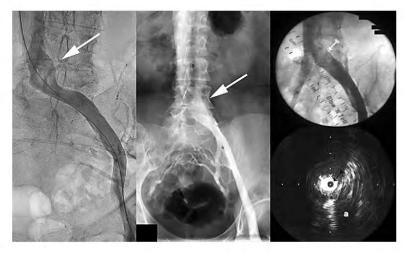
Variable venographic appearance of nonthrombotic iliac vein lesions (NIVLs). Left, "Classic" appearance with contrast translucency appearing as a filling defect (arrow). Middle, Broadening (pancaking) of the vein with collaterals (arrow). Right, the venogram appears entirely normal in about a third of cases. Note the absence of collaterals. However, an intravascular ultrasound (IVUS) scan showed a tight lesion (inset) with the lumen not larger than the 6F IVUS catheter (arrow); "a" denotes adjacent artery. The arrow in the venogram points to the general area where the IVUS found the NIVL.
